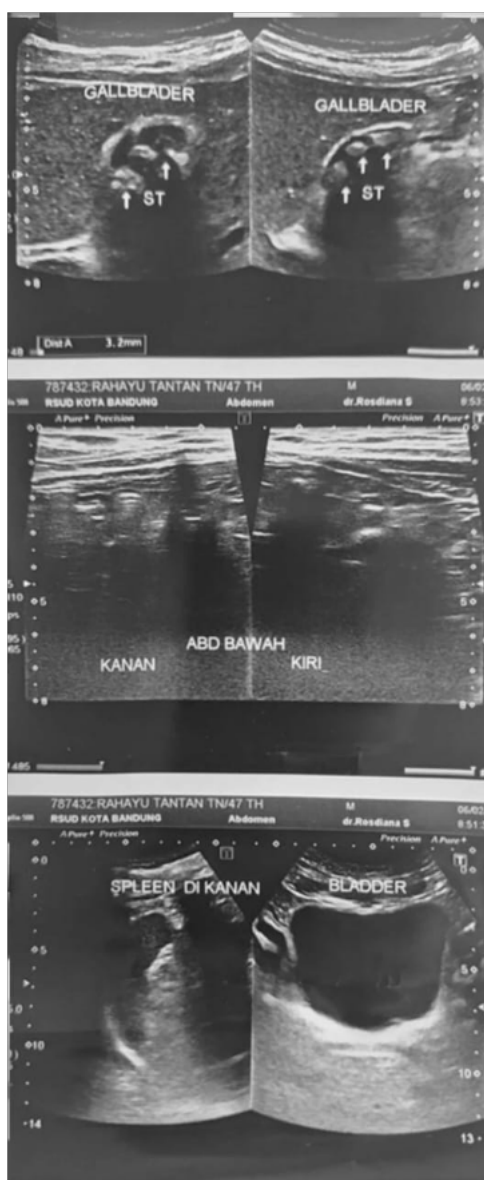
Abdominal ultrasound showing the liver located on the left side.
